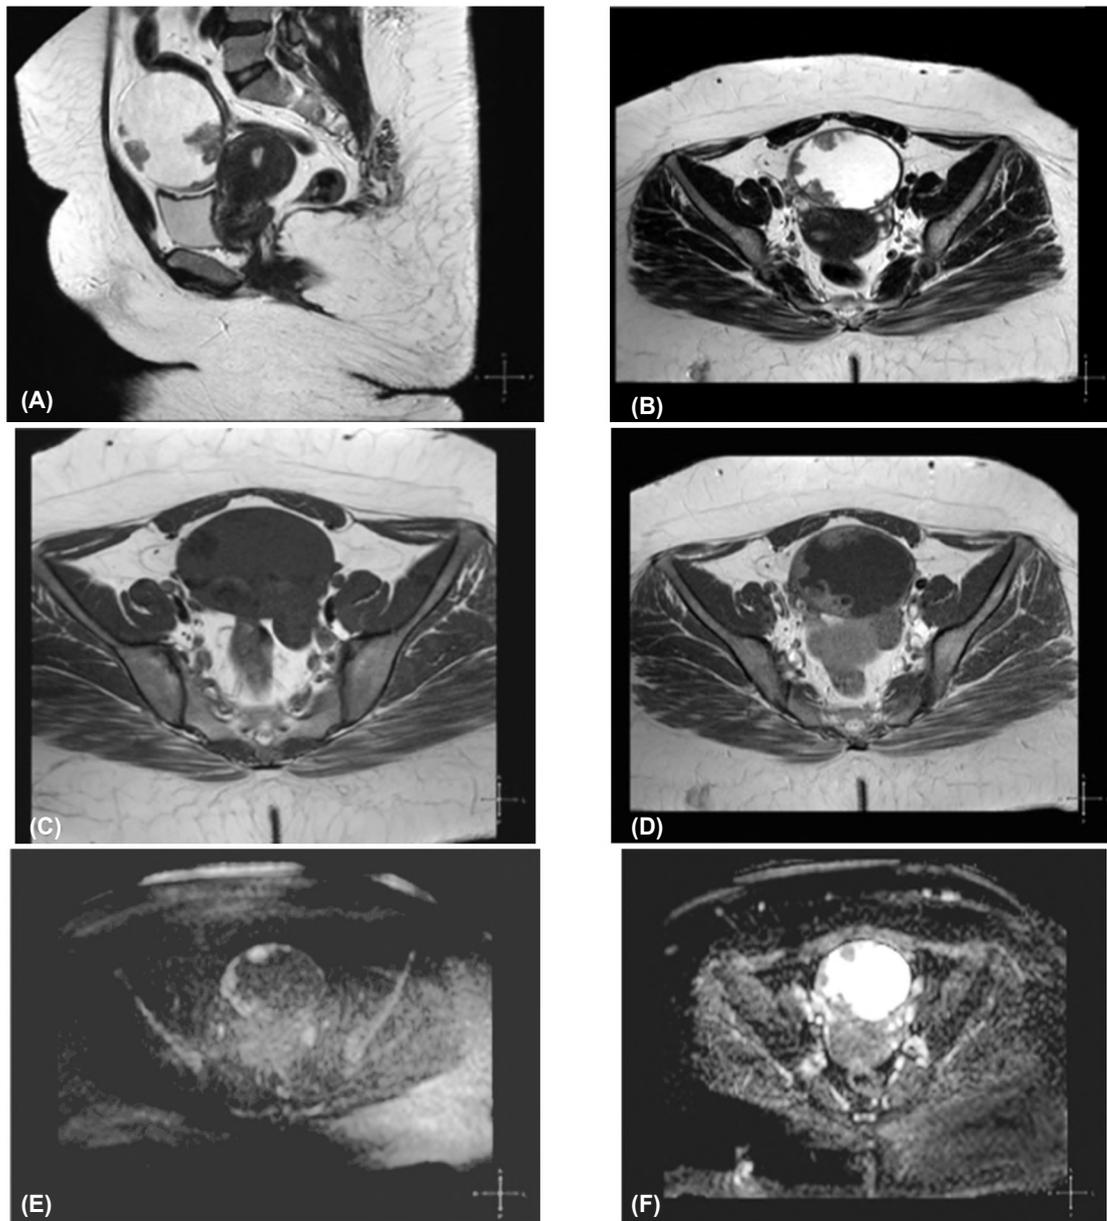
Patient aged 57 years. (A) Sagittal T2 WI, (B) Axial T2 WI, (C) Axial T1WI, (D) Axial T1 post-contrast (E) DWI (b-value=1000sec/mm²), (F) ADC map. A complex cystic adnexal mass is seen just anterior to the uterus with multiple papillary projections. It elicits low signal intensity on T1WI, high signal on T2WI. Enhancement of the tumor vegetations is observed. The ADC value was 1.03 X 10⁻³ mm²/s. Final diagnosis: Borderline papillary serous cystadenoma.
